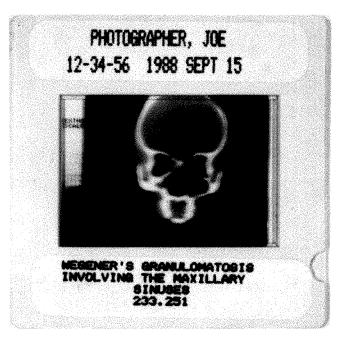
Magnified appearance of a 2 \times 2 in. (5 \times 5 cm) standard radiographic slide with labels applied.
